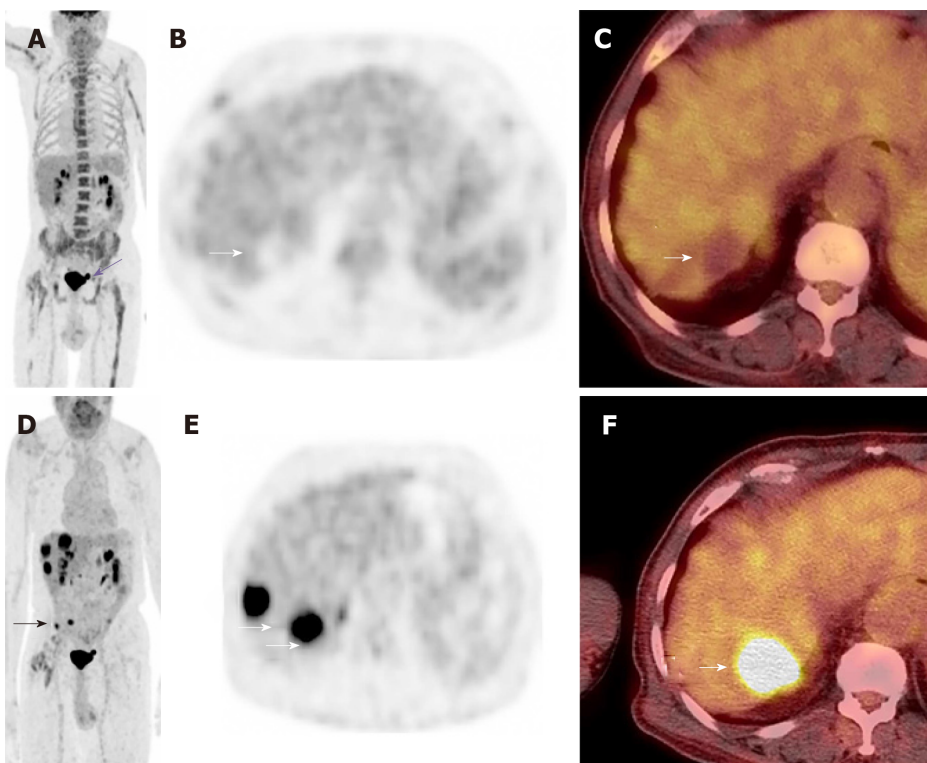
A restaging skull base to mid-thigh fluorodeoxyglucose positron emission tomography/computed tomography scan was performed after injection of 4.9 mCi of fludeoxyglucose 2 mo following Yttrium 90 radioembolization. The post Yttrium 90 treatment positron emission tomography (PET) maximum intensity projection (MIP) coronal (A), attenuation corrected axial (B) and fused axial (C) PET images show complete resolution of all lesions with focal photopenia in the right hepatic lobe (white arrowheads). Incidentally, there is chemotherapy induced diffuse skeletal uptake and a small urinary bladder diverticulum (purple straight arrow A). The pre-therapy Positron emission tomography images are provided for comparison. Coronal MIP image (D) axial attenuation correction (E), and fused axial (F). Pretreatment PET images show multiple fludeoxyglucose avid right lobe hepatic (white arrows) and peritoneal (black arrows) lesions. PET: Positron emission tomography; MIP: Maximum intensity projection.
